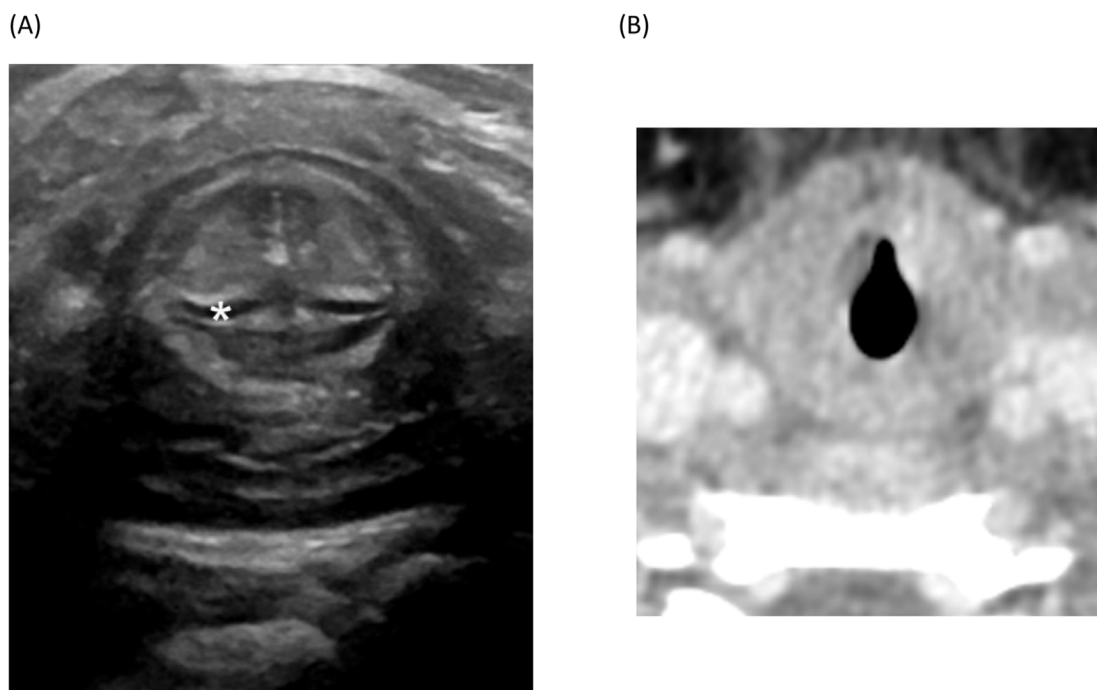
Transverse plane ultrasound in a 9-month-old boy (A) and companion enhanced CT in a 4-year-old girl (B) at the level of the vocal folds. In A, the folds touch at the midline, at rest, with horizontal, wide U-shaped hypochoic lines which are the edges of the paired arytenoid cartilage (*). While CT provides very little soft tissue resolution, high resolution ultrasound provides exquisite definition of tissue planes.
